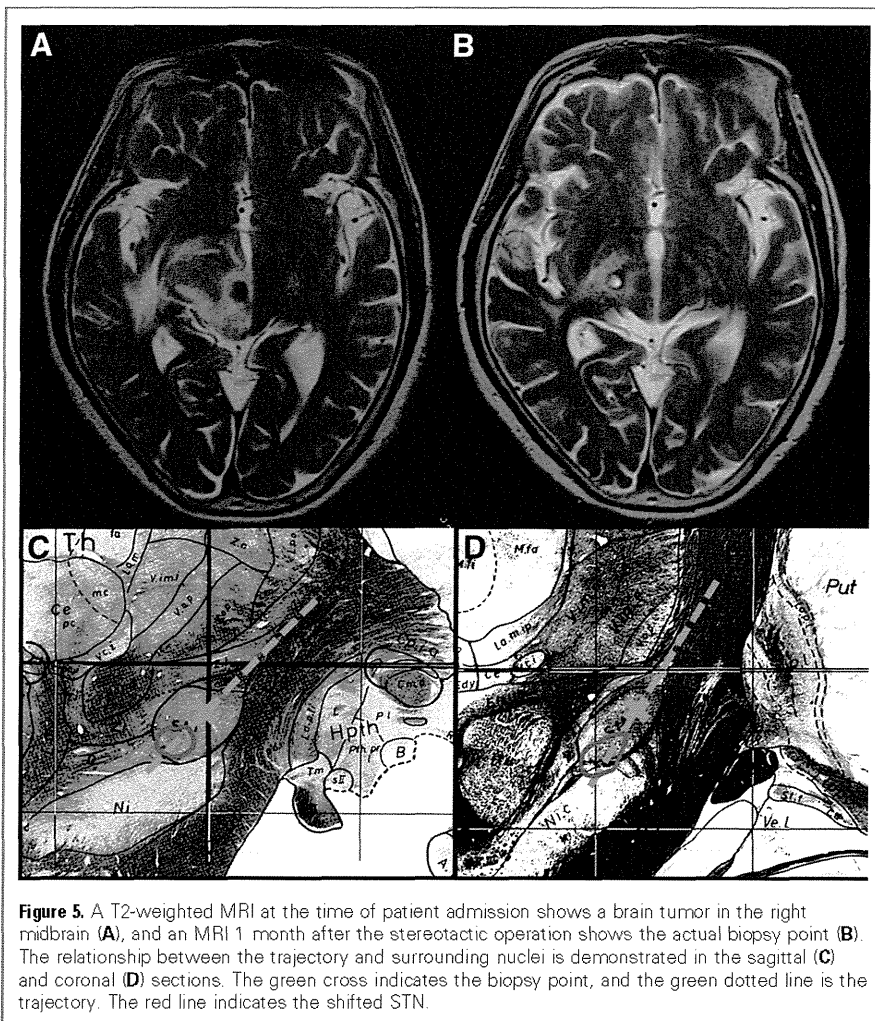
A T2-weighted MRI at the time of patient admission shows a brain tumor in the right midbrain (A), and an MRI 1 month after the stereotactic operation shows the actual biopsy point (B). The relationship between the trajectory and surrounding nuclei is demonstrated in the sagittal (C) and coronal (D) sections. The green cross indicates the biopsy point, and the green dotted line is the trajectory. The red line indicates the shifted STN.
